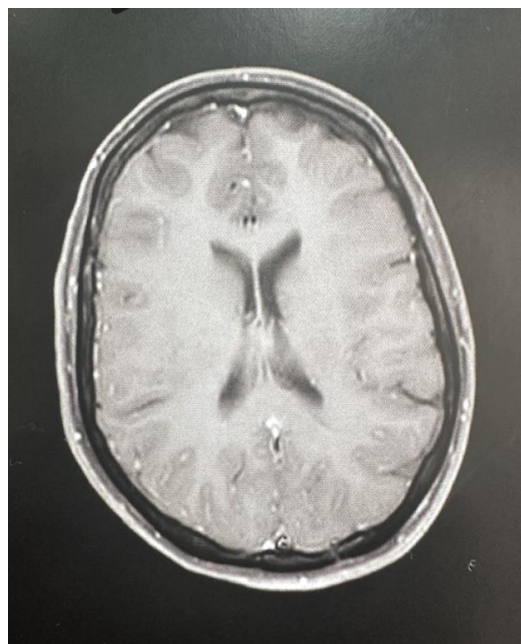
Cerebral MRI showing no abnormalities
